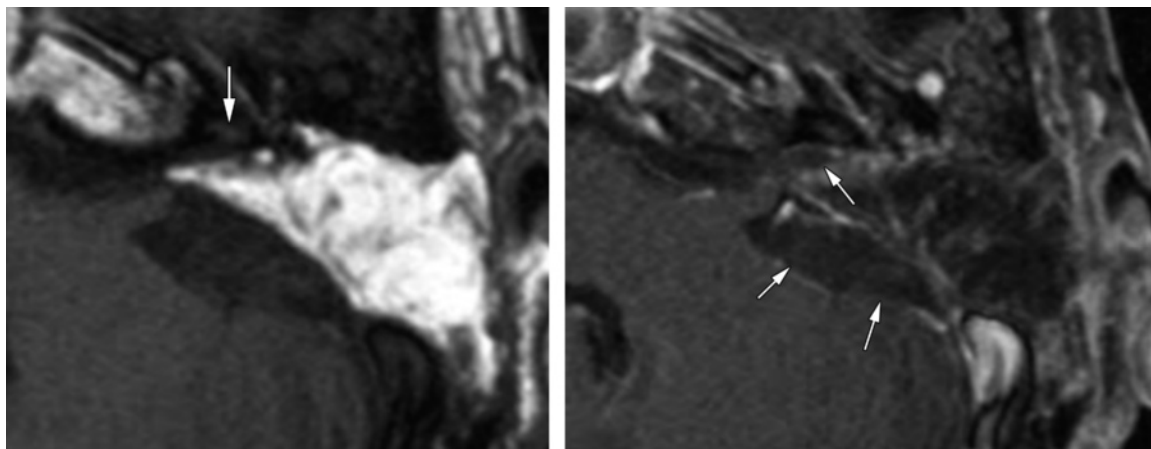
Translabyrinthine fat graft. (a) Axial nonenhanced spin-echo T1-weighted MR image shows the typical appearance of a translabyrinthine fat graft. The cochlea is intact (arrow). The inherent high T1 signal of the fat can be problematic on contrast-enhanced images. Fat-saturated images are usually needed to distinguish fat from residual tumor in patients who have undergone translabyrinthine resection. (b) Axial contrast-enhanced fat-saturated T1-weighted MR image of the fat graft shows faint enhancement along the graft margins (arrows), which represents a normal postoperative finding.
